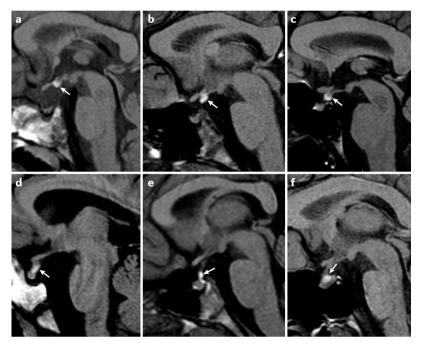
Pathological MRI in children with hypopituitarism. Sagittal T1-weighted images showing the classic triad of ectopic posterior pituitary (arrows; associated with a variable location), median eminence (parts a, b), mid-pituitary stalk (parts c, d) with a double posterior pituitary (part e) and distal stalk (parts e, f). The pituitary stalk is absent (parts a, b, c), or hypoplastic or thin (parts d, e, f). The anterior pituitary is of variable size from severe hypoplasia (parts a, b) to mild hypoplasia (parts c-f). Current practice points for MRI work-up in patients with hypopituitarism are as follows. MRI without contrast medium using T2-DRIVE sequences of the hypothalamic-pituitary region and the entire brain (forebrain, midbrain and hindbrain) is highly recommended in neonates, infants and children with signs and symptoms suggestive of hypopituitarism (such as hypoglycaemia, cholestatic jaundice and other signs). First-line MRI examination without growth hormone (GH) testing could be performed. MRI is also highly recommended in children and adolescents with severe short stature and GH testing compatible with a diagnosis of GH deficiency (GHD), in children and adolescents with multiple pituitary hormone deficiency, and in children with isolated GHD (IGHD) and severe short stature (developing pituitary defects are possible over time). MRI could be of low value in children with IGHD and less severe GHD defined based on the local GH cut-off (>3, >5, >7 or >10 ng/ml). A personalized decision is advisable.
